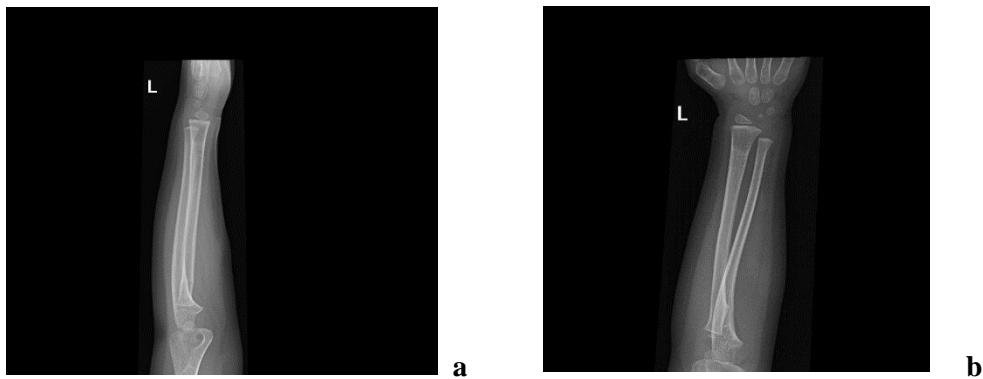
(a and b) X-ray of the left Forearm.
